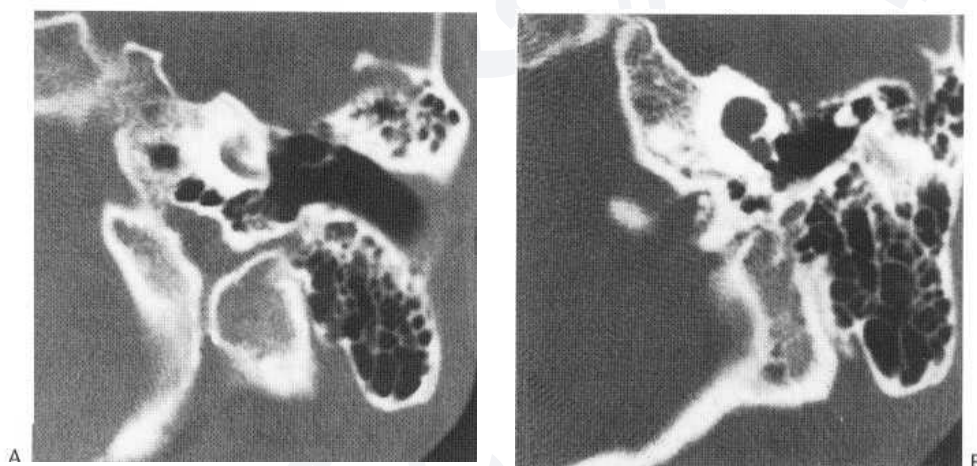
Two basal CT sections showing a normal basal turn of cochlea (A) and distal sac (B), i.e. a true Mondini deformity. Some hearing was present and the normal basal turn suggests no risk of fistula or meningitis.
